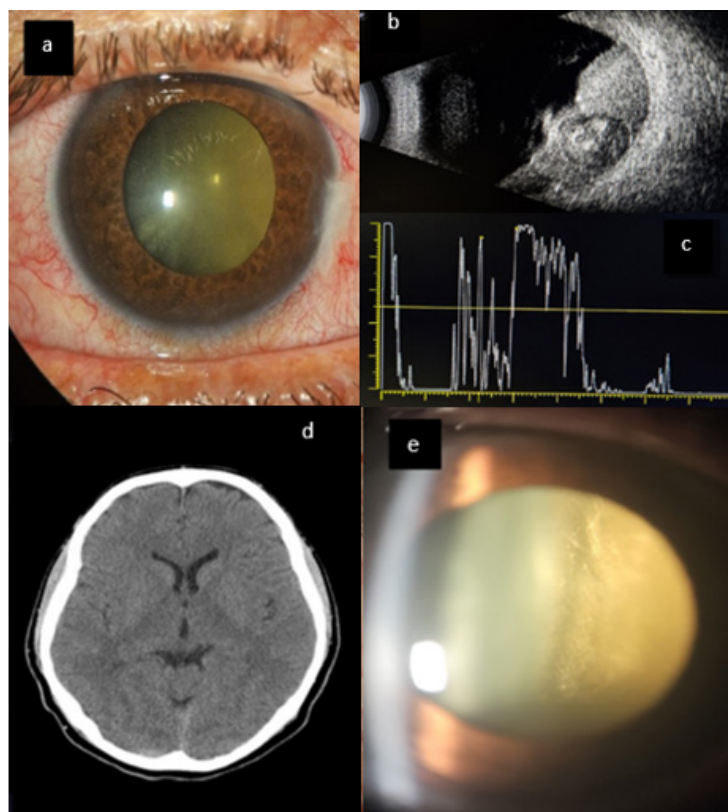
Slit lamp examination, Ultrasound and Tomographic Findings
